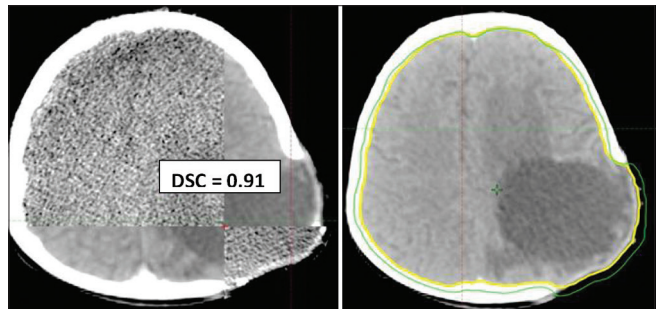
CBCT registered with CT of a brain cancer patient with post operative edema. Green: DIR generated contour, Yellow: RO drawn contour
